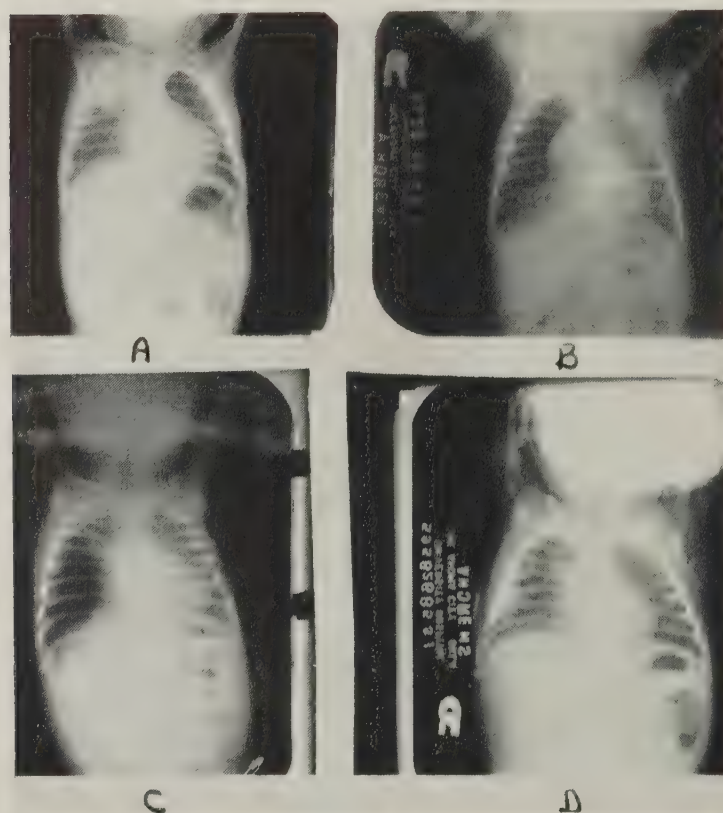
Shown are serial chest roentgenograms in a patient with staphylococcal pneumonia. A, infiltration and consolidation on admission, B, depicts large pneumothorax (right); C, shows beginning development of large pneumatocele (right); D, decrease in size of pneumatocele.
